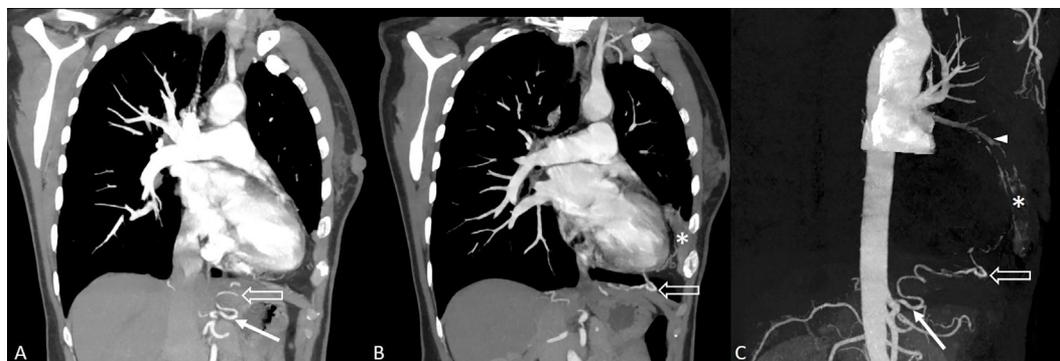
(A and B) Coronal oblique view contrast-enhanced computed tomography angiography (CTA) of the chest and (C) maximal intensity projection (MIP) with three-dimensional volume rendering (3D-VR) shows intralobar pulmonary sequestration in the inferior lingula segment of the left upper lobe (asterisk) which blood supply from a left inferior phrenic artery (open arrow) that arising from left gastric artery (arrow) and draining in to the left superior pulmonary vein (arrowhead).
